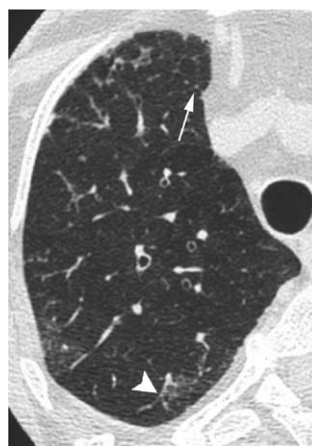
HRCT of the chest (left upper lobe) showing centrilobular nodules (arrow), bronchiectases, and branching linear opacities (arrowhead).
